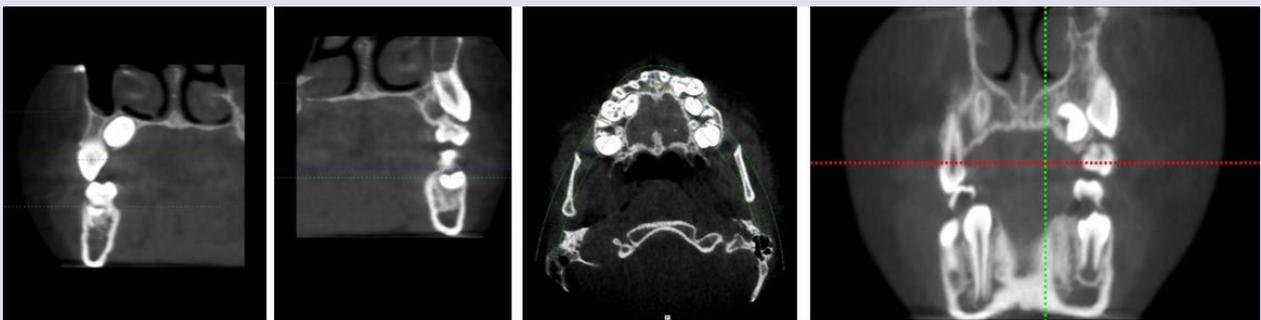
CBCT images showing impacted teeth.
